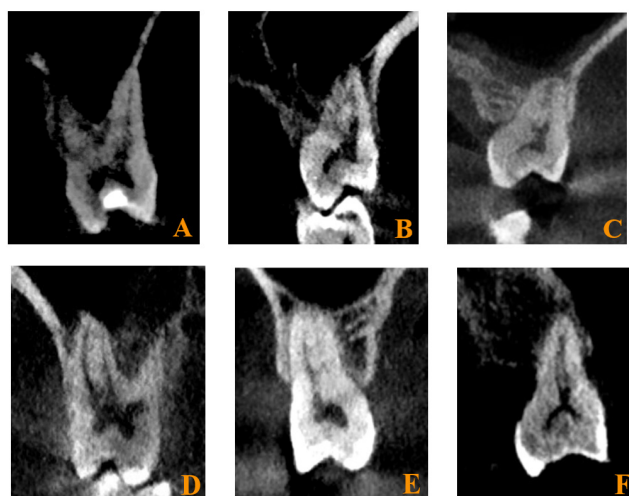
Representative CBCT images in cross-sectional (A-F) views, displaying mesiobuccal root canal morphology of the maxillary first molar according to the Vertucci classification. A. Type I; B. Type II; C. Type III; D. Type IV; E. Type V; F. Type VI. Type VII and VIII were not identified in this study.
